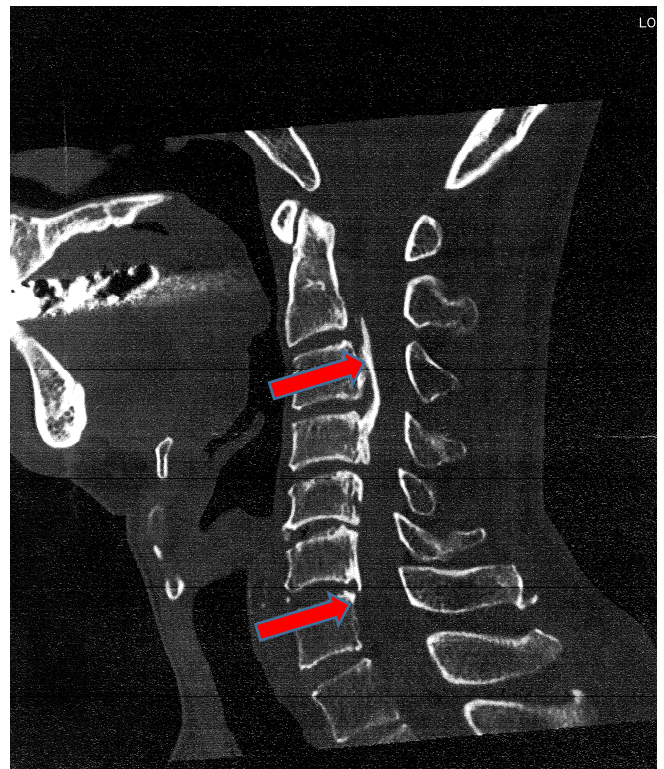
Case 1, CT image:
